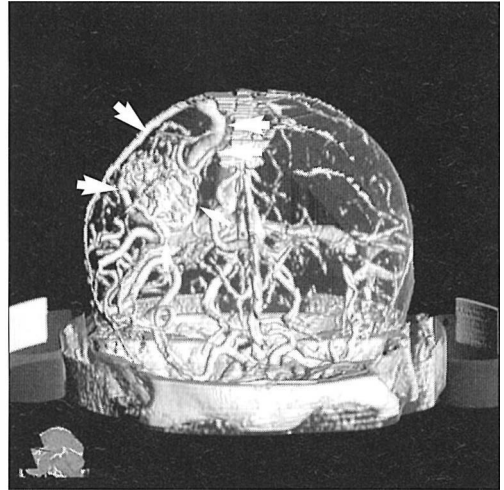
CT angiogram, volume rendering technique, anteroposterior view, shows pial arteriovenous malformation of the right hemisphere. Two main feeding arteries (arrows), nidus (arrowheads) and draining vein (open arrow) are well demonstrated.
